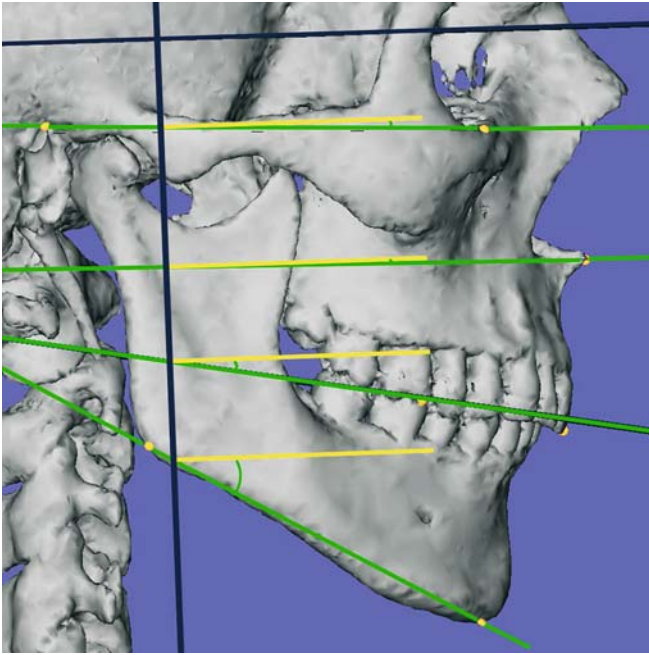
The lateral inclinations of the Frankfort horizontal plane (FH-PI), the maxillary plane (Mx-PI), the occlusal plane (Occ-PI) and the mandibular plane (Md-PI) from the horizontal (x) 3-D cephalometric reference plane are projected angular measurements on the median (z) 3-D cephalometric reference plane (3-D CT, hard tissues, patient K.C.)
